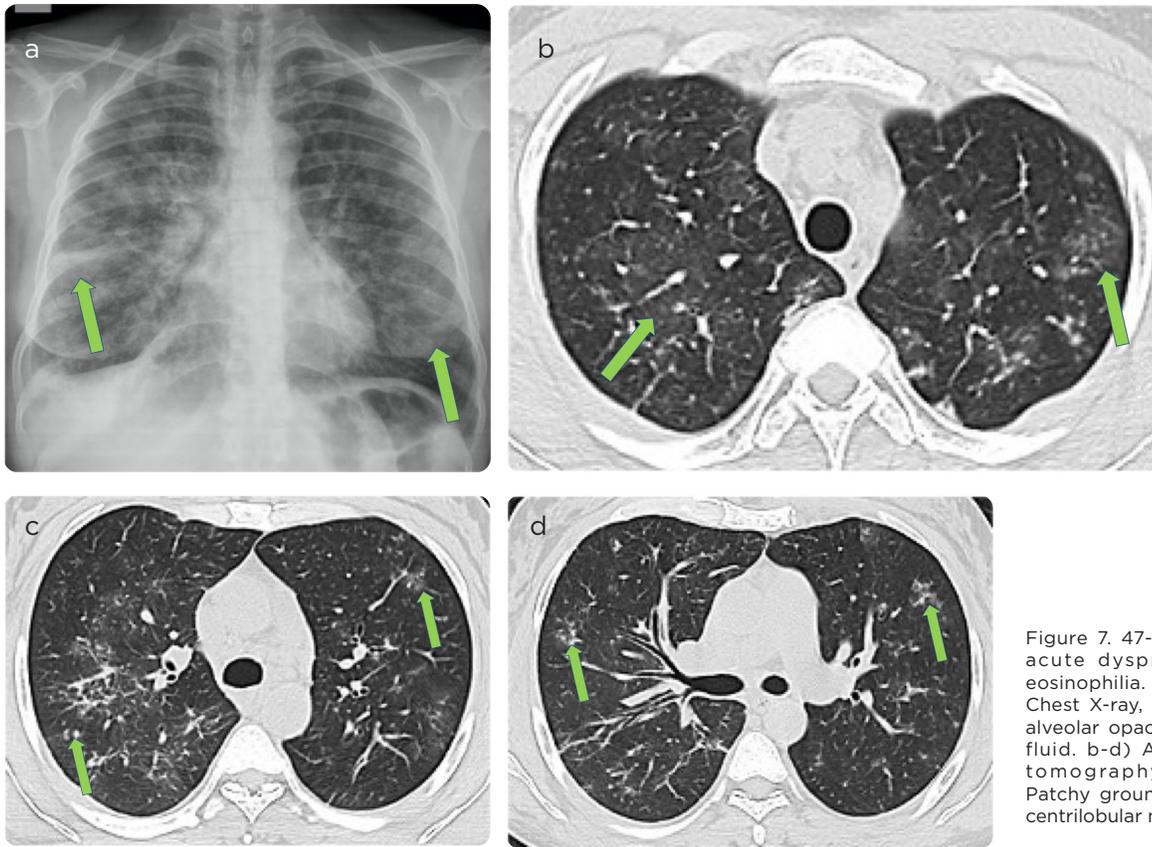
47-year-old woman with acute dyspnea and peripheral eosinophilia. History of asthma. a) Chest X-ray, PA projection. Patchy alveolar opacities and right pleural fluid. b-d) Axial mages of chest tomography in lung window. Patchy ground-glass opacities and centrilobular nodules.
